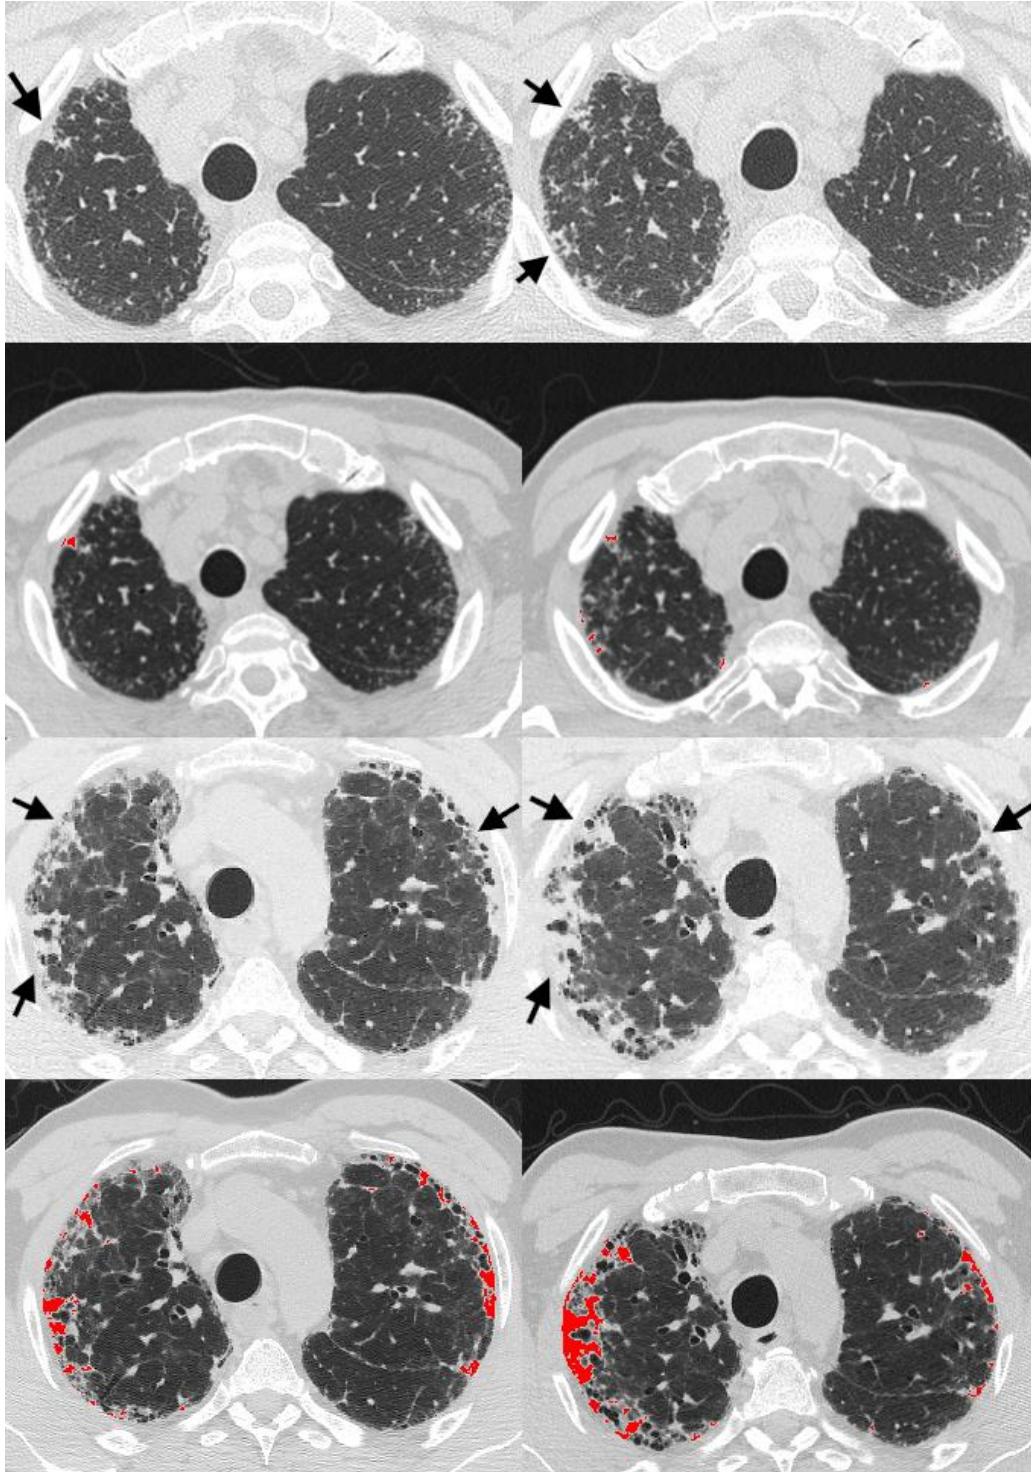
Visual characteristics of progressive PPFE. Baseline (left column) and follow up (right column) CT scans in patients diagnosed with idiopathic pulmonary fibrosis by multidisciplinary team. The top two rows show axial CT images of the upper zones taken 13 months apart in a 73-year-old male with normal baseline FVC (83%) and DLco (74%). Arrows (top row) show areas of PPFE increasing in extent on the second CT, also highlighted by image overlays of PPFE regions (second row). The bottom two rows show axial CT images taken 9 months apart in a 54-year-old male with abnormal baseline FVC (46%) and DLco (35%). Arrows (third row) show more extensive PPFE proliferating dramatically on the second CT, again highlighted on image overlays of PPFE regions (bottom row).
